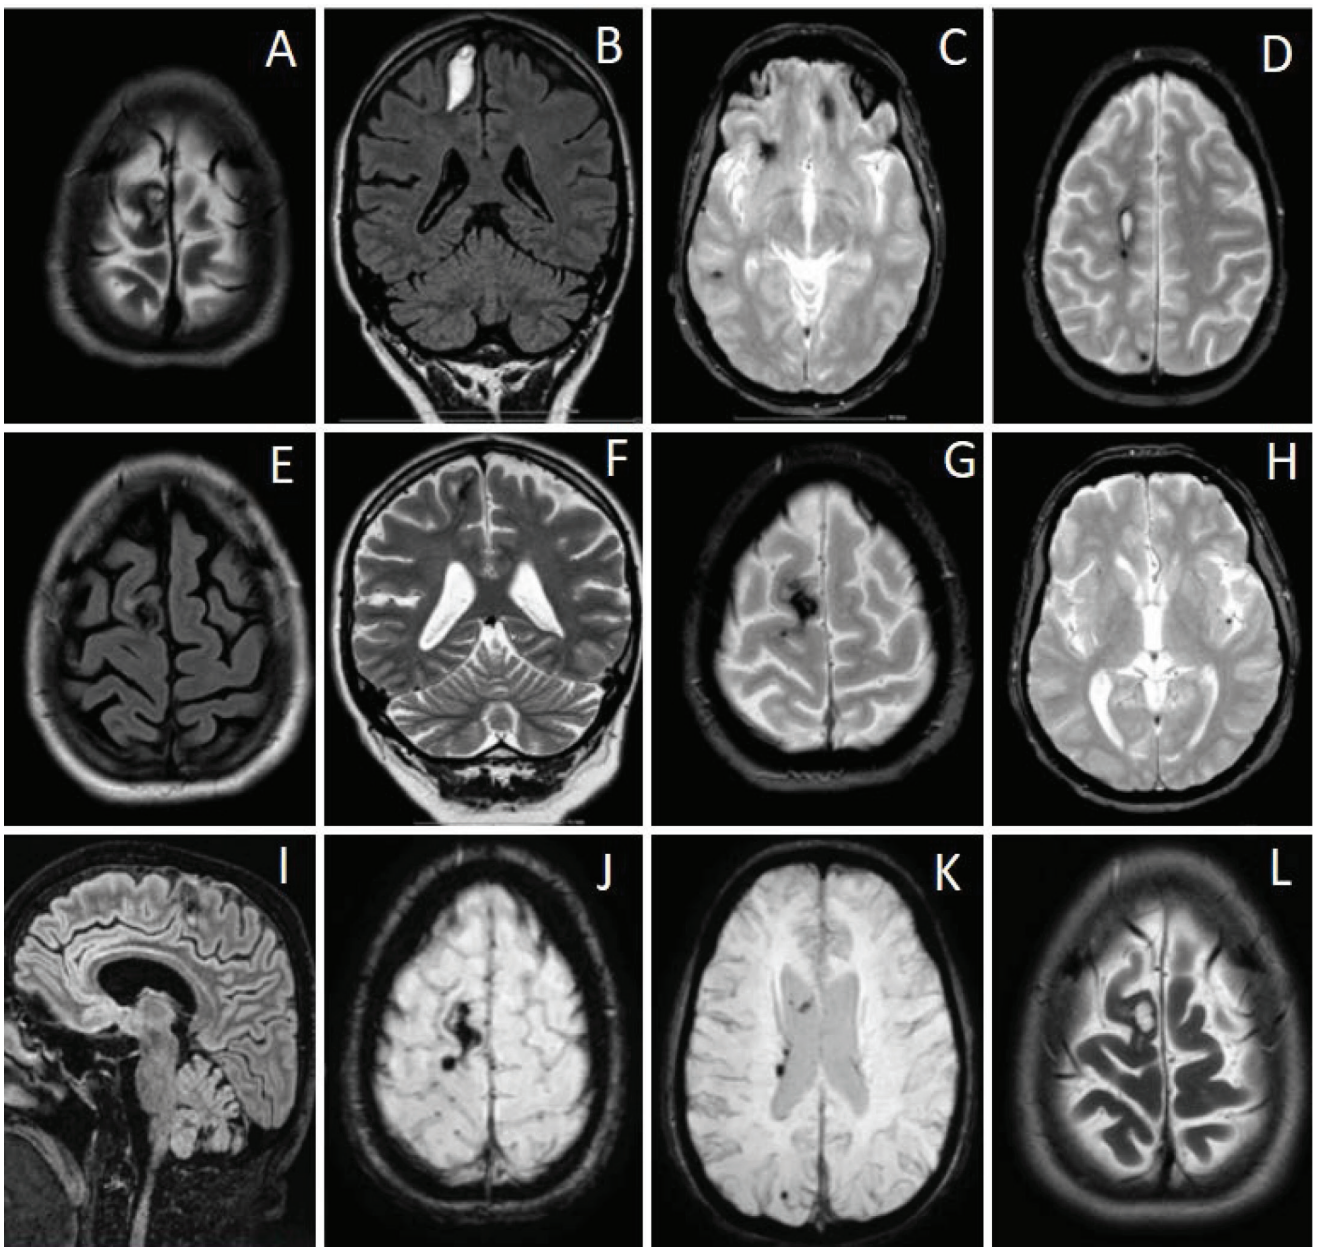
A: axial T2-Weighted TSE: 2cm AP/3cm CC/1,2cm LL sub-acute right superior frontal hemorrhagic lesion; B: coronal FLAIR: hyper intensity of the same frontal lesion; C: axial T2 FFE right temporal hypo intensity that corresponds to a right cavernoma; D: axial T2 FFE right frontal and parietal hypo intensities; E: axial FLAIR: 12x7mm right superior frontal cavernoma with a mild perirolandic expansion (resorption of the intralesional hemorrhagic component comparing with the images from 2021); F: coronal FLAIR: hypo intensity of the same frontal lesion with mild surrounding hyper intensity corresponding to gliosis; G: axial T2 FFE nodular hypo intense lesions that corresponds to residual hemosiderin deposits; H: T2 FFE left insular cavernoma; I: sagittal FLAIR: right superior frontal cavernoma with hemoglobin degradation compounds at interior and perilesional gliosis; J,K: axial SWI: supratentorial nodular lesions compatible with right frontal and parietal cerebral cavernomas; L: axial T2 right frontal cavernoma
